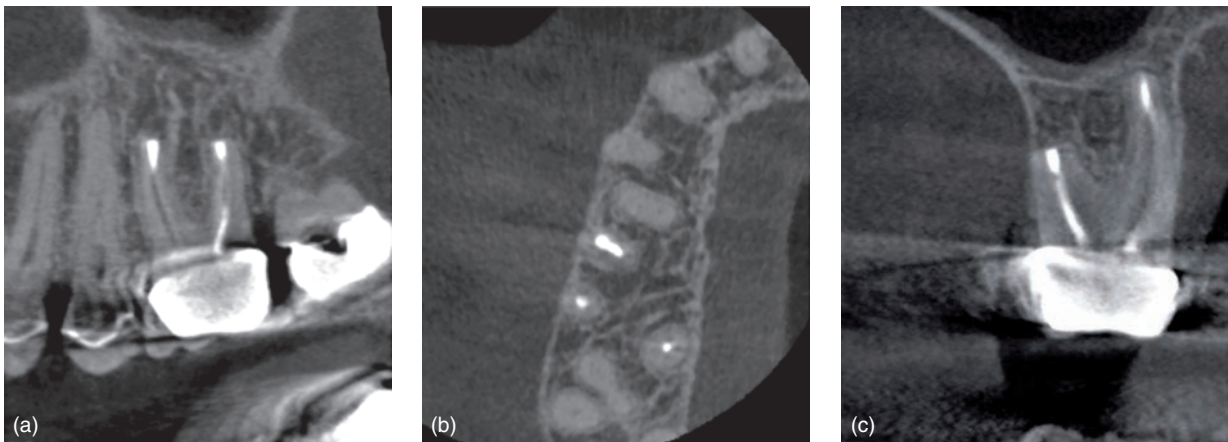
Example of complete healing after endodontic microsurgery: CBCT analysis and 2.5 year follow-up of maxillary first molar. (a) Sagittal view; (b) axial view; (c) coronal view.
